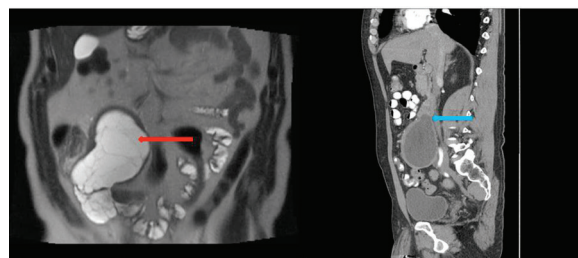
Left image shows T2-weighted coronal image of the cystic mass in the right lower quadrant. Red arrow indicates the mass. Right image shows a sagittal image of a CT scan with contrast. Blue arrow demonstrates close proximity with the duodenum and retroperitoneum with the cystic mass.
